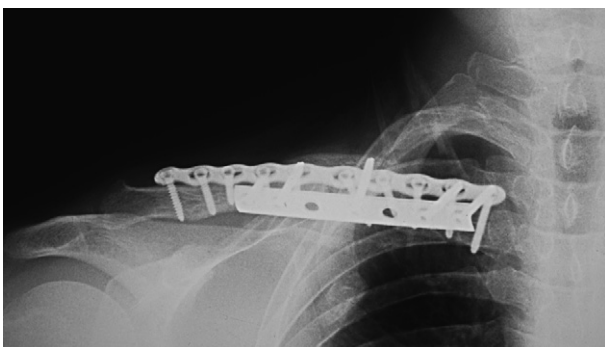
Radiograph of the third surgical fixation shows a 10-hole plate placed on the superior aspect of the clavicle, and 2, stacked, 6-hole plates placed on the anterior aspect of the clavicle. Callus was not obvious on these radiographs.
